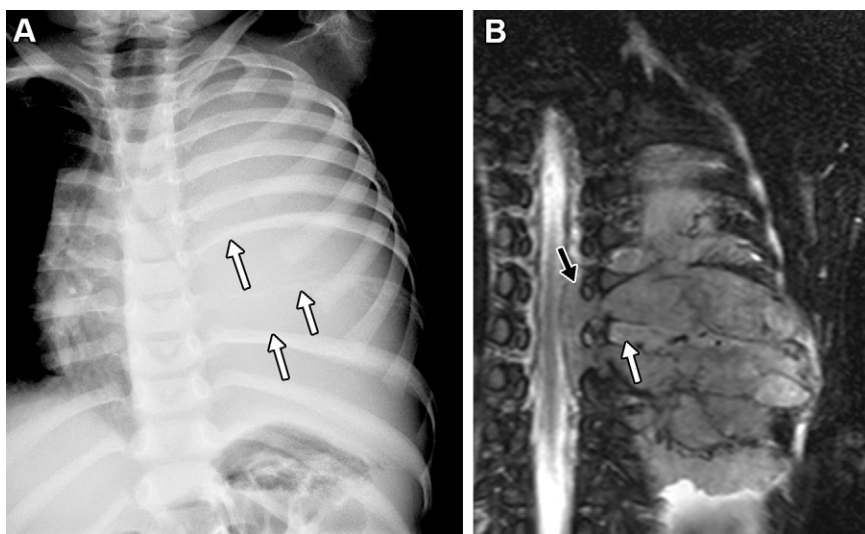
Neuroblastoma of the posterior mediastinum with rib involvement in a 3-year-old boy. (A) Frontal chest radiograph shows a complete opacification of the left hemithorax with a tracheal deviation to the right. The posterior segment of the left seventh, eighth, and ninth ribs is eroded (white arrows) with permeative destruction extending into the lateral segment of the eighth rib. (B) Coronal fat-suppressed T2-weighted MR image shows an extensive posterior mediastinal mass spreading through the extrapleural space, extending into the spinal canal (black arrow) and invading the eighth rib (white arrow).
